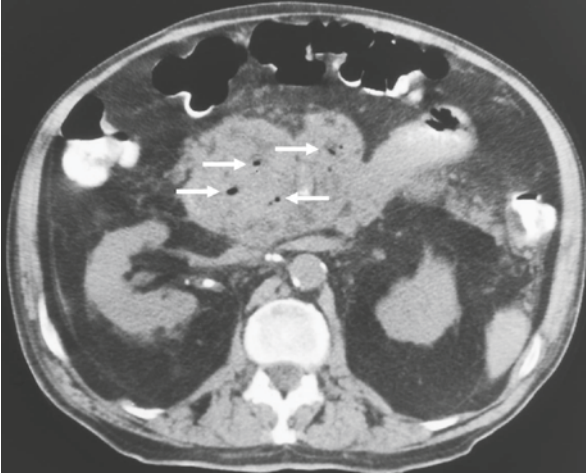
Computed tomography of the abdomen showing areas of extraluminal gas (arrows) in the setting of AP
